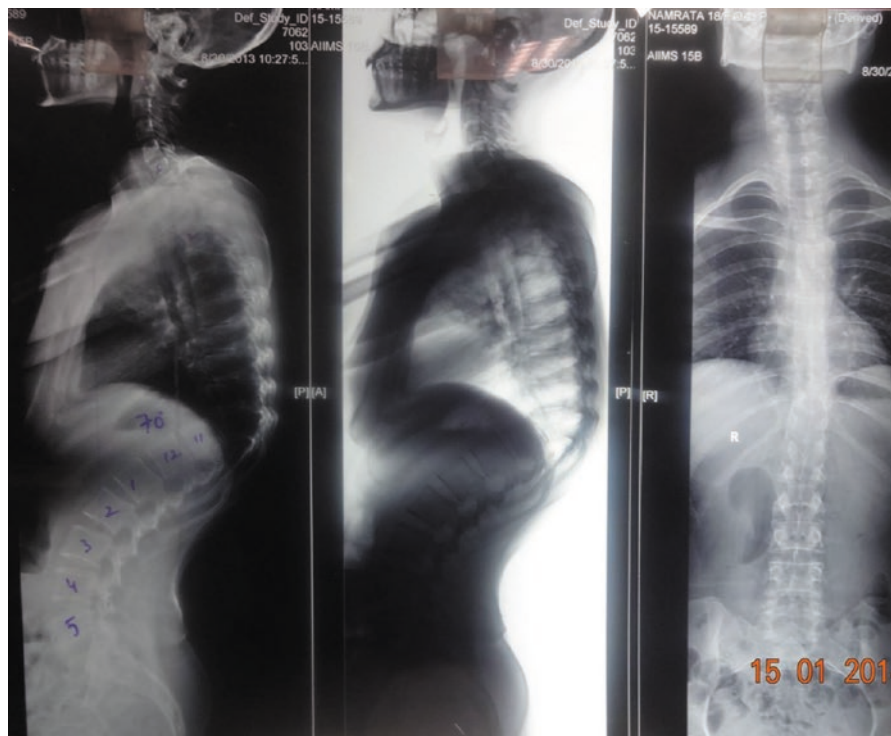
Pre-operative radiograph, post-operative radiograph, and intra-operative images of a 20-year-old female with thoracic kyphotic deformity following healed tubercular disease involving D9 vertebrae who underwent Pedicle Subtraction Osteotomy for deformity correction with posterior instrumentation. Preoperative radiograph of a 20-year-old female with post-tubercular kyphotic deformity involving D9 vertebrae
